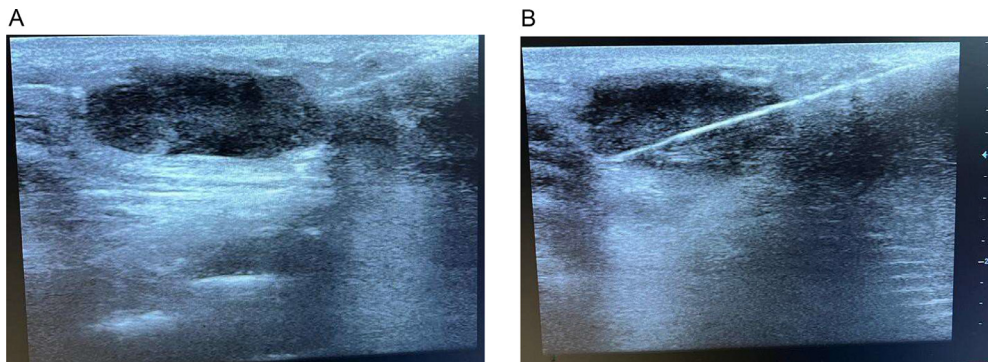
(A and B) Ultrasound-guided biopsy of the metastatic nodule.
